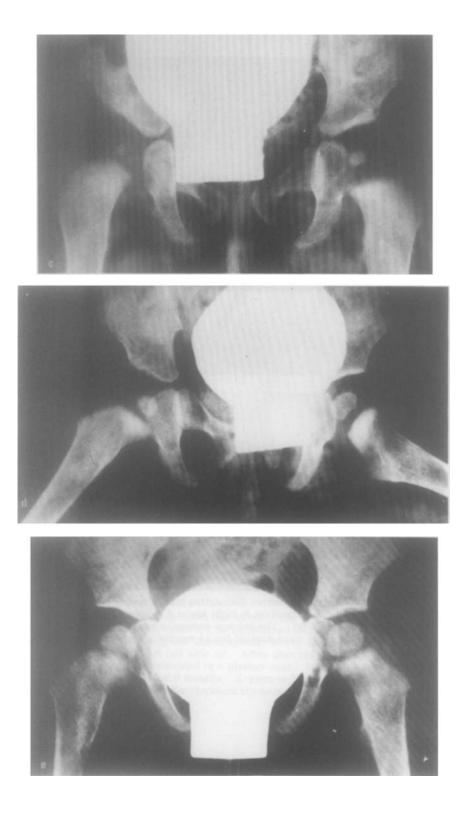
Girl with a distinctly positive dislocation test in both hips at birth and treated initially with the Frejka pillow. X-ray at 3 months of age shows dislocation on the right side (a). Reduction by skin traction failed (b), and the hip was reduced operatively at 5 months, followed by plaster casts for 15 months. X-rays at 6 months (c), at 10 months (d), and at 20 months (e) show development to normal hips.
